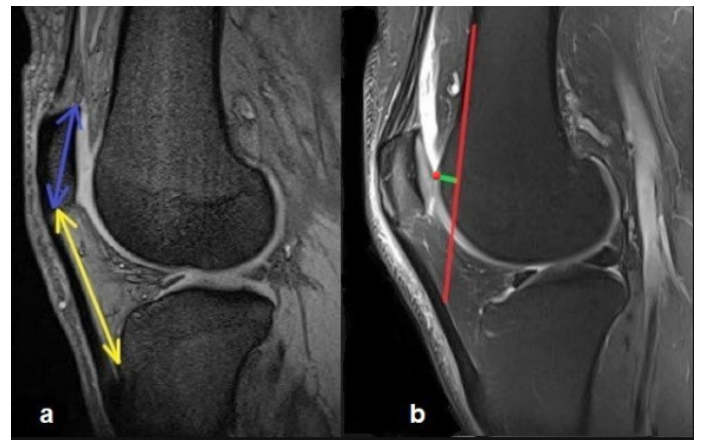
Sagittal magnetic resonance images shows; (a) Insall–Salvati ratio: Patellar tendon length (yellow line)/Patellar length (blue line), (b) Ventral trochlear prominence: is the distance (green line) between the line paralleling the ventral cortical surface of the distal femur (red line) and the most anterior cortical point of the femoral trochlear floor (red point).
